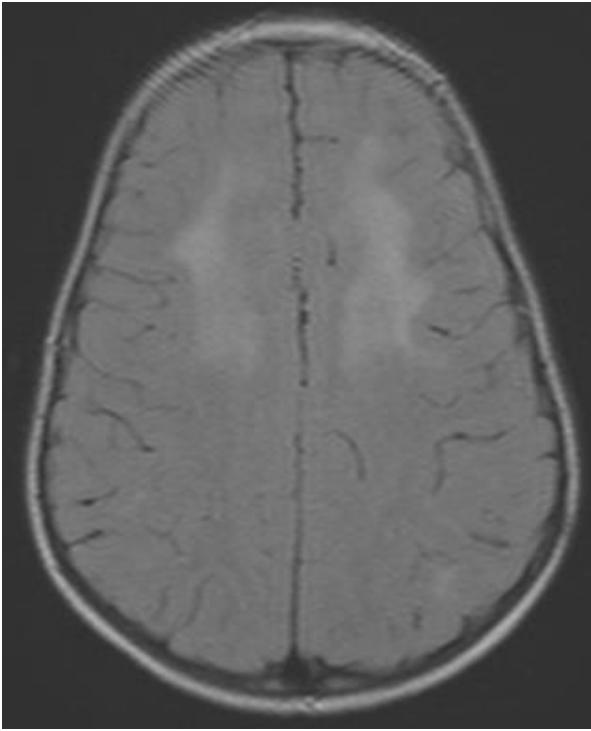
MRI brain of a 20-month old child with HIV encephalopathy showing white matter enhancement.
